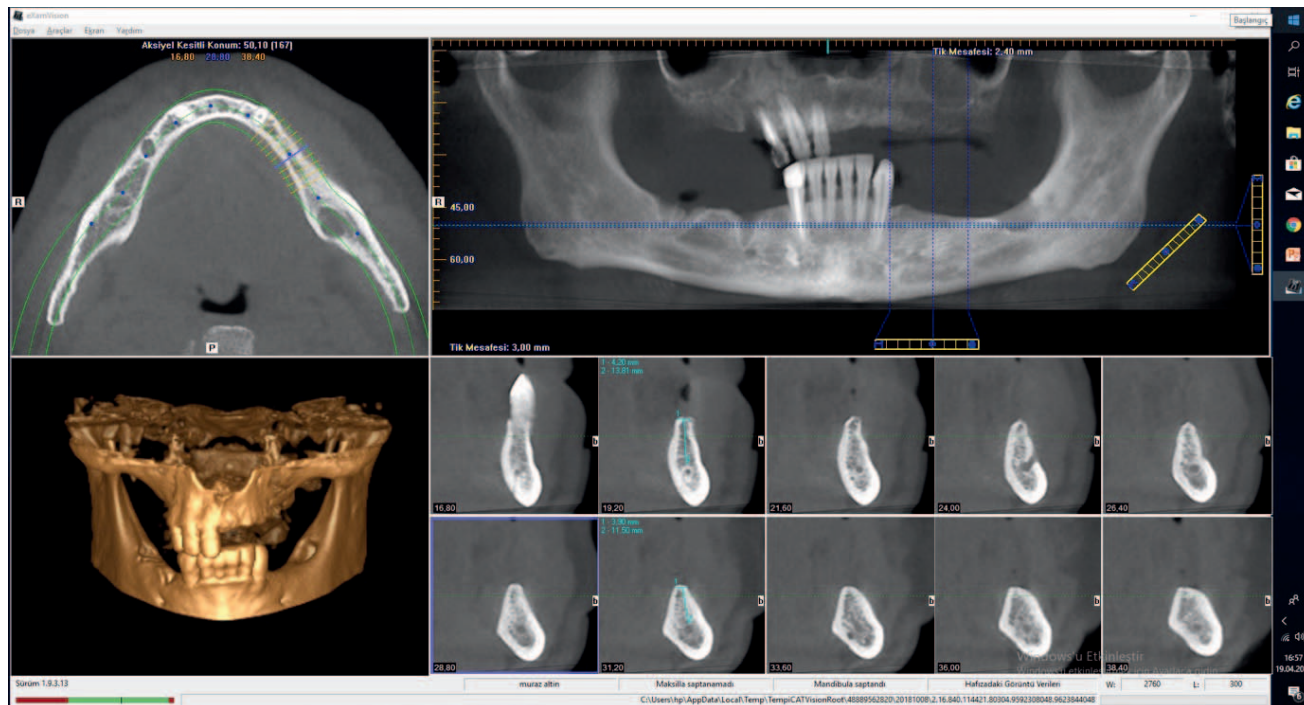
Preoperative cone-beam computerized tomography image.
